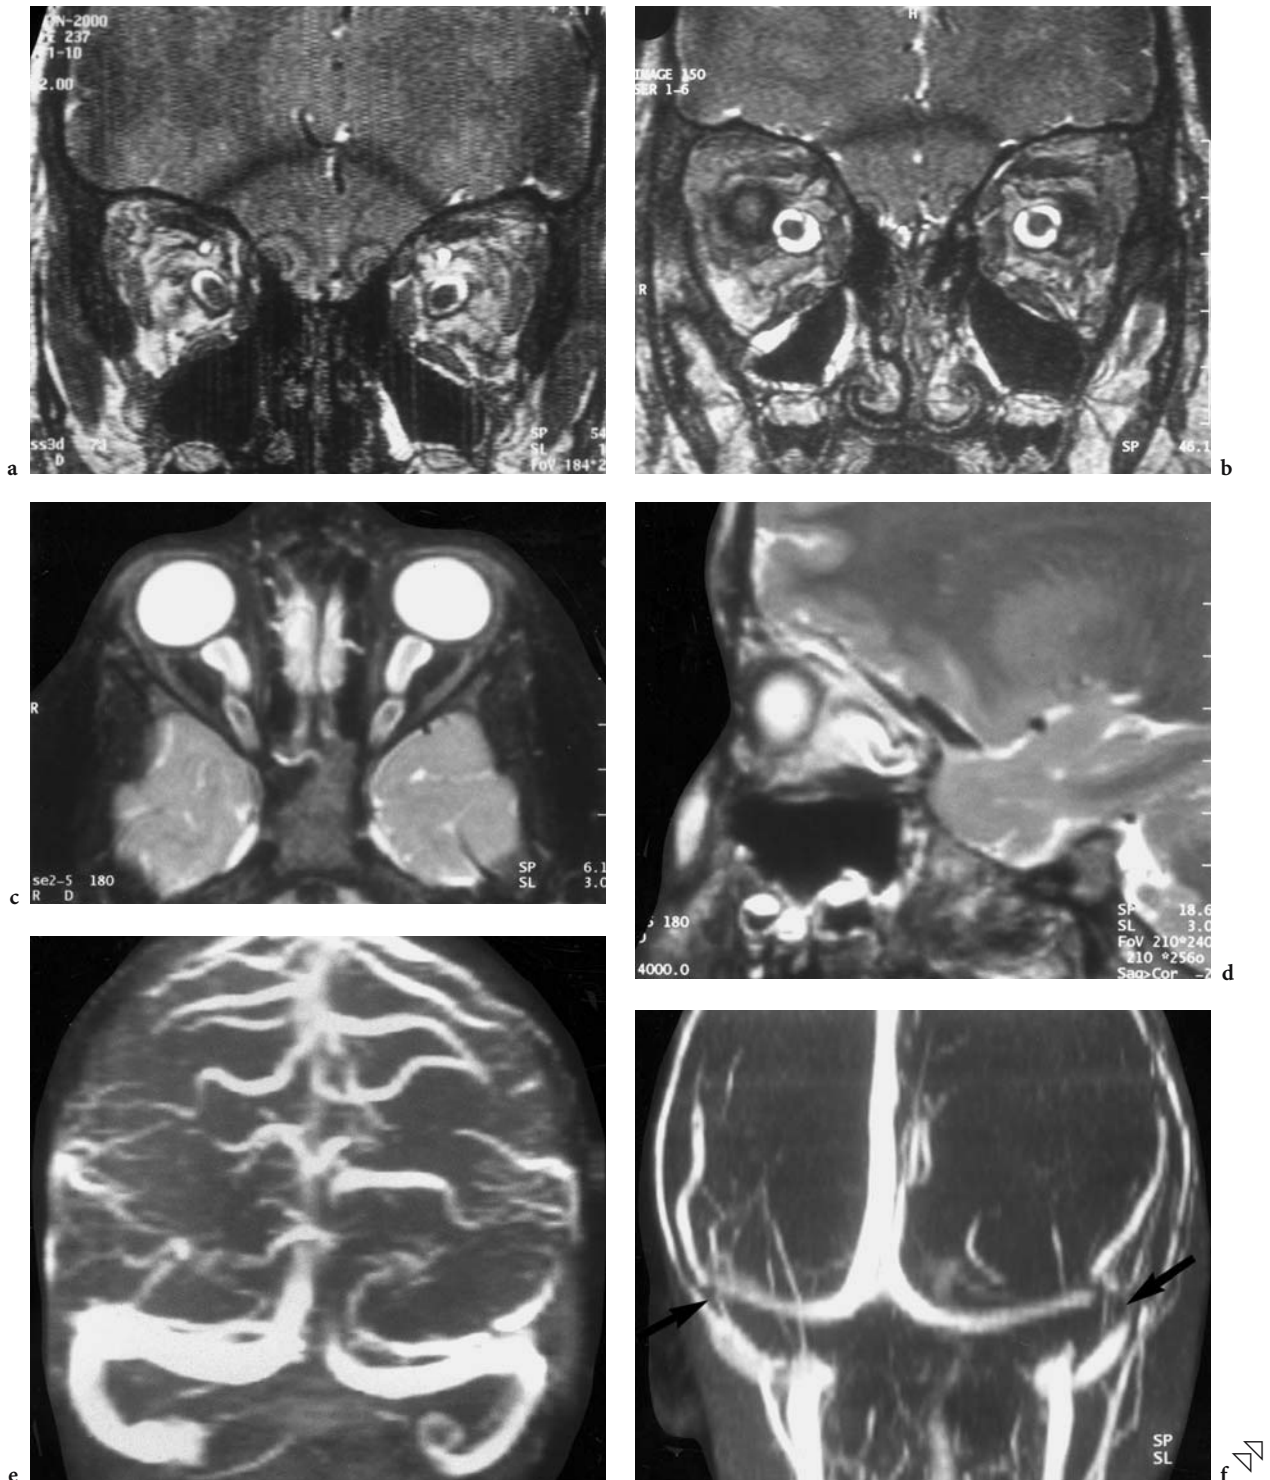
Course of a 3-year-old boy with papilledema, indicating the presence of a cerebral pseudotumor. Clinical normalization of the symptoms was observed after treatment with diamox. Diagnosis: cerebral pseudotumor. MRI: a Coronal T2-weighted HR view of the optic nerve with only slight dilation of the subarachnoid space. b Corresponding view 2 months after treatment, demonstrating a substantial enlargement. c Axial T2-weighted view taken at the same time, also showing enlargement of the optic nerve sheath and kinking of the nerve, better seen on the sagittal view. d Sagittal T2-weighted view of the right optic nerve. e MIP reconstruction of a TOF venous MR-angiography at the time of the onset of symptoms; no pathology is detectable. f Corresponding venous MRA 2 months later, showing apparent narrowing of both sigmoid sinus regions. DSA: g venous phase of the left ICA, confirming the findings of MRA by the presence of bilateral venous outflow stenosis (arrows). h Venous manometry showed a pressure gradient of 5 mmHg for the pre- and poststenotic (not shown) sinus area
